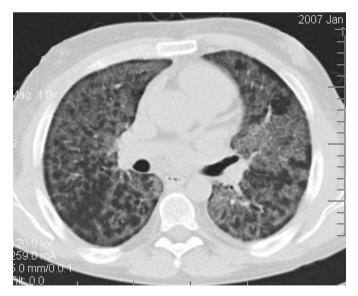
The high-resolution computed tomography scan shows diffuse geographic ground-glass attenuation with superimposed interlobular septal and intralobular interstitial thickening in a mosaic pattern (the so-called "crazy paving" appearance).
